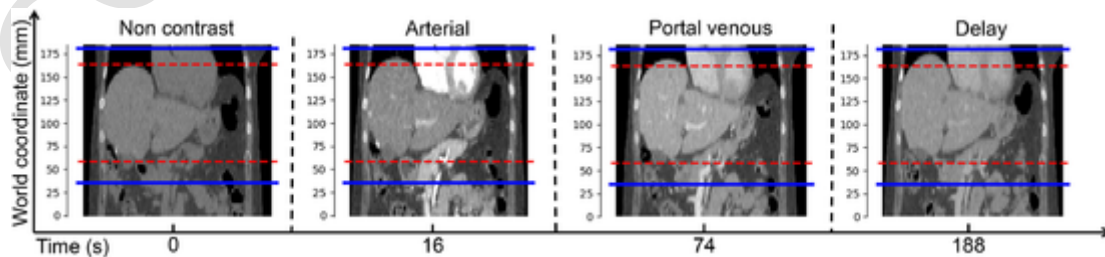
The liver motion in a multiphase CT image of the liver: the scans were performed at four specific time points. The red dashed lines depict the live range in the first CT image and the blue solid lines indicate the delineated scan range. Note that in this study, we applied the delineated scan range on the arterial image and delayed image based on the Goldman's protocol. (For interpretation of the references to colour in this figure legend, the reader is referred to the web version of this article.)
